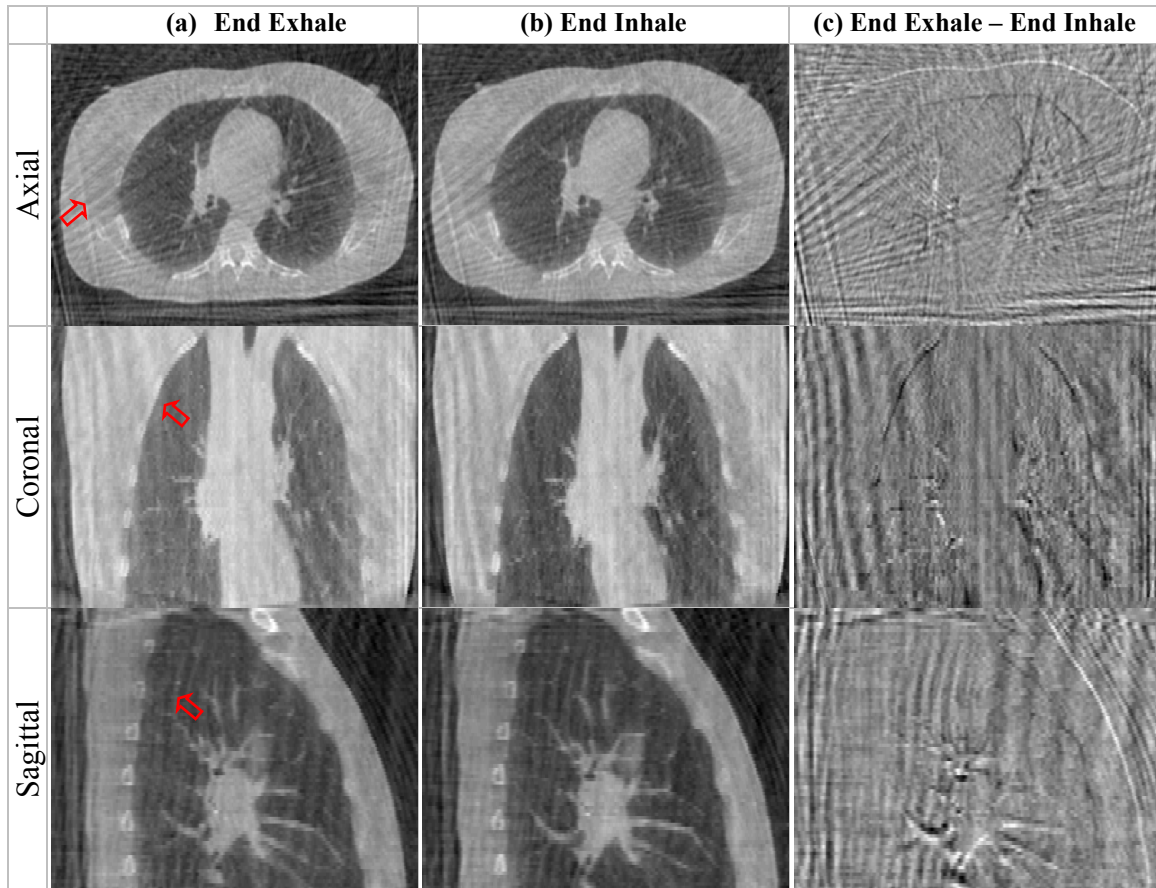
4D-CBCT Reconstruction from projections of Patient 2 in two different phases
